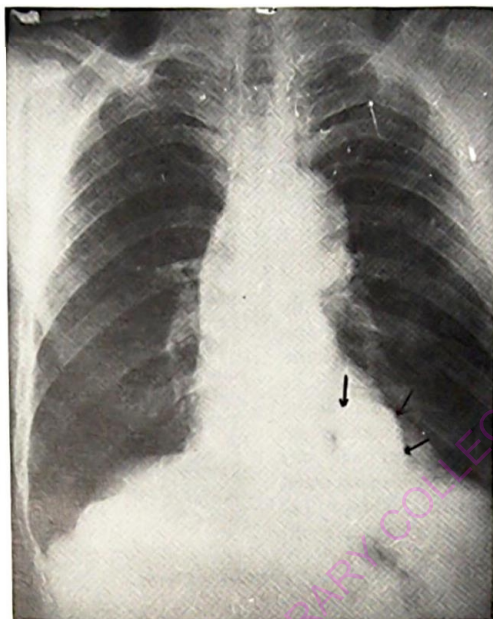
P. A. Chest radiograph showing a smooth rounded mass through the cardiac silhouette, continuous with left diaphragmatic outline (arrows).
